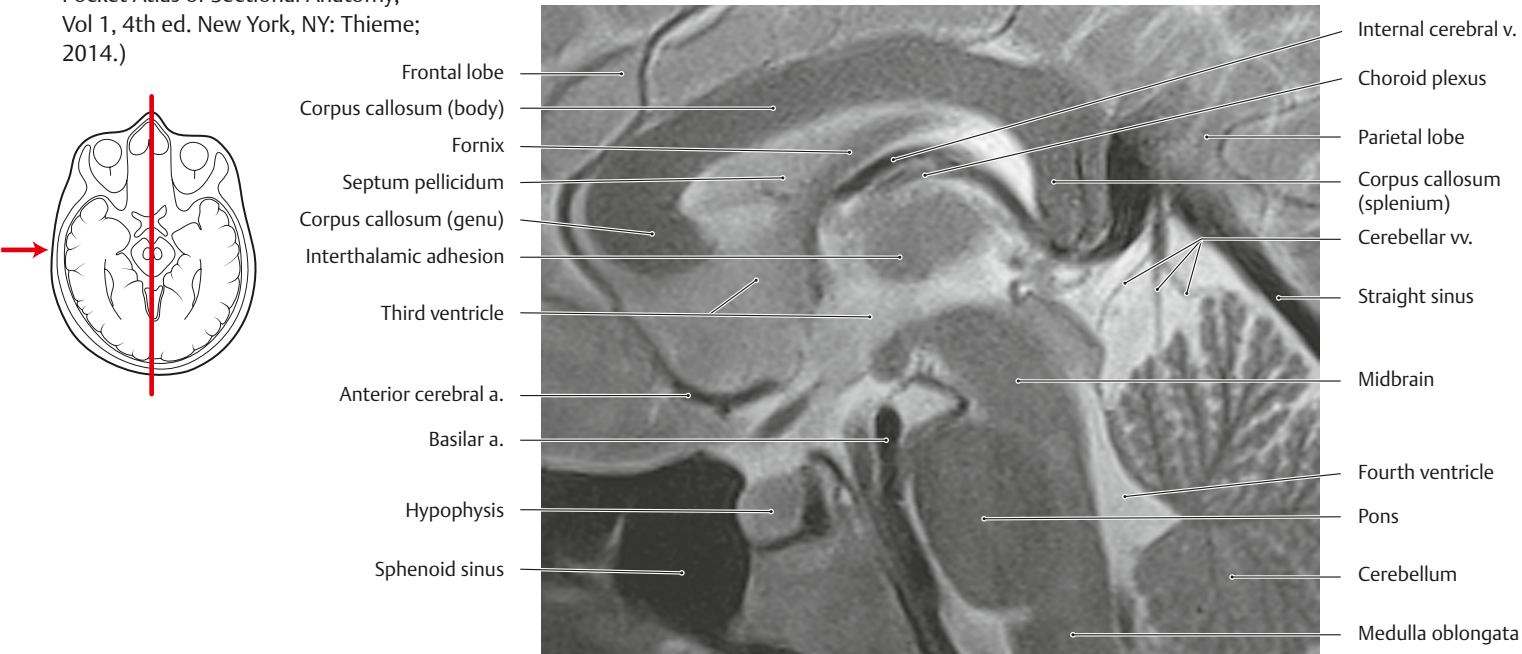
MRI of the brain
